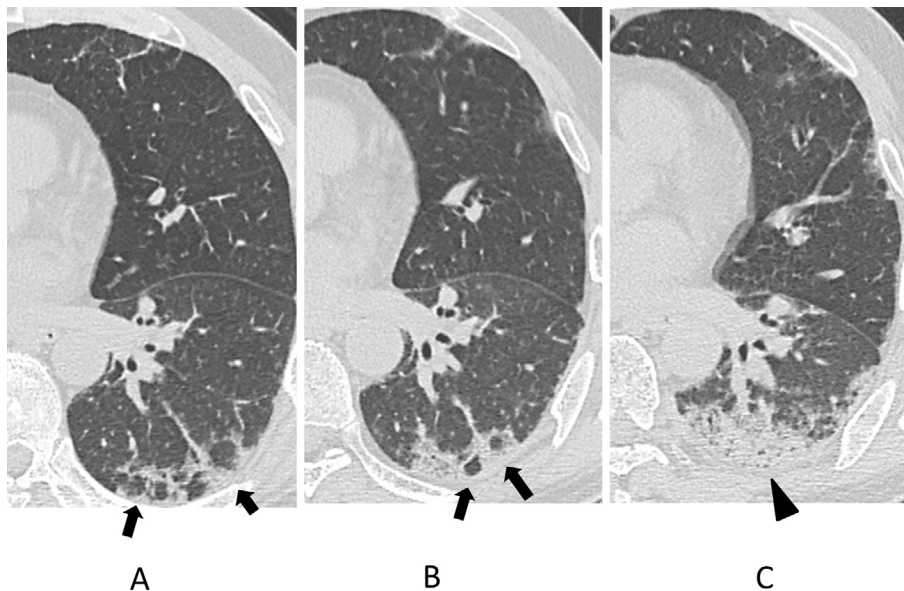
Follow-up CT findings in Case 4. (A) Perilobular opacity was revealed in the left lower lobe of Case 4 (arrows). The area of the radiological abnormality was localized. (B) The perilobular opacity observed on admission deteriorated with thickening in two weeks (arrows). (C) The perilobular opacity progressed to consolidation with the loss of lung volume in one month (arrowhead).
